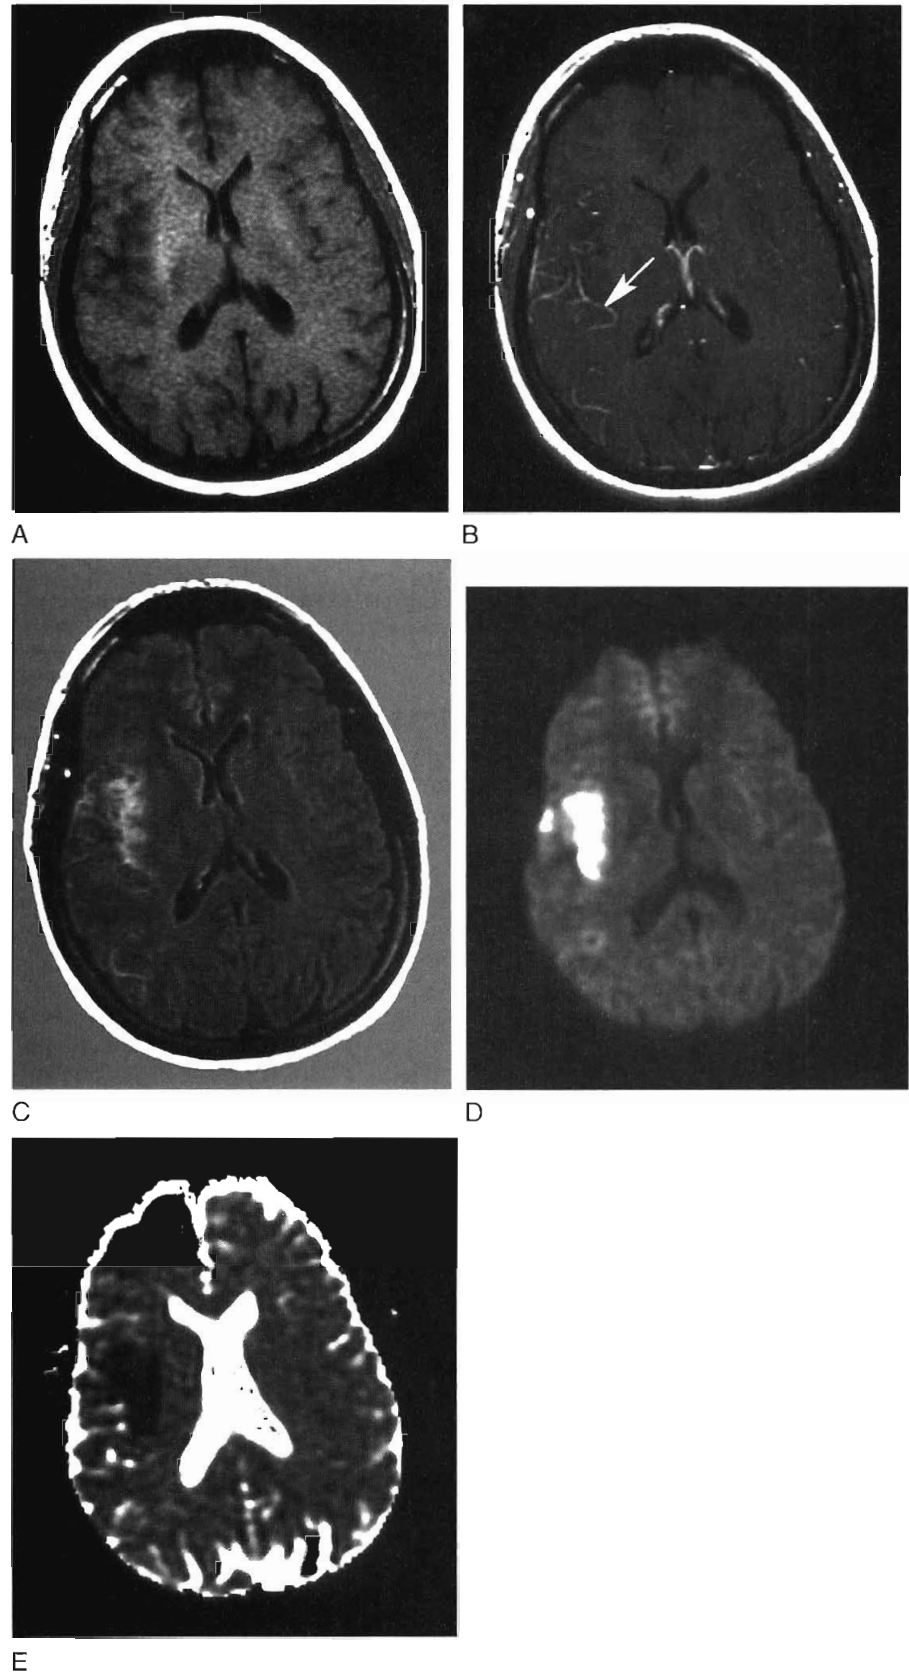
Hyperacute infarct. Axial T1-weighted images before (A) and after (B) contrast administration reveal subtle low intensity and arterial enhancement (arrow) in the right insular cortex. The fluid-attenuated inversion recovery (FLAIR) sequence (C) helps define the area of involvement. The diffusion-weighted sequence (D) shows the infarct to the best advantage. The acute phase is confirmed by the low signal on the apparent diffusion coefficient map (E).
